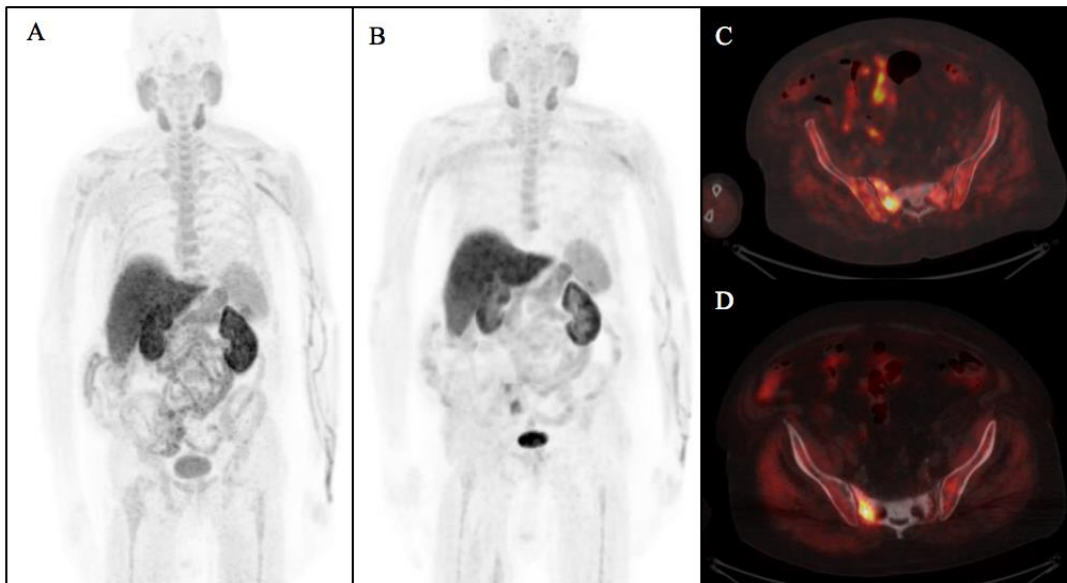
^{18}F -FCH PET/CT (A) MIP and (C) axial fused images pre-treatment and (B) MIP and (D) axial fused image post-treatment performed in an 83 years old patient affected by CRPC, GS 8. Ra223 therapy has been preceded by only abiraterone, but because he was evaluated before the new EMA guidelines, he was enrolled for this kind of therapy. (A, C) Pre-treatment evaluation showed low tumor burden (<20 bone lesions). He started and completed Ra223-therapy. (B-D) Post-treatment ^{18}F -FCH PET/CT showed stable disease and he had an improvement in clinical symptom (slight vs moderate pain).
